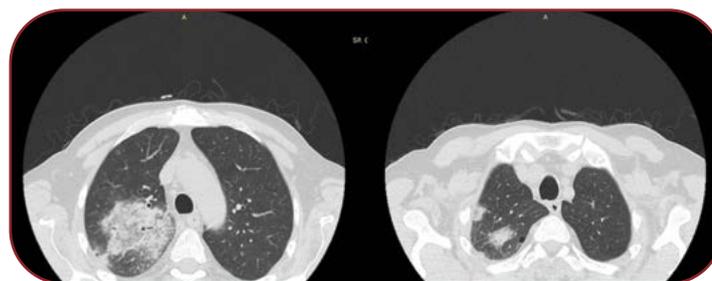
First CT scan – four nodular opacities were described
